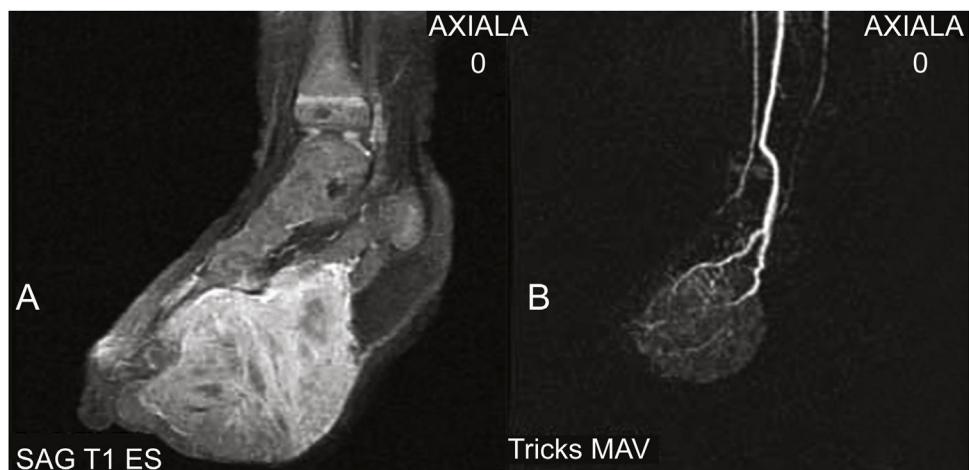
(A) MRI identifying an expansive mass with diffuse contrast enhancement. (B) MRA showing an expansive lesion supported by vascular structures. There is no evidence of arteriovenous fistulas or nidus.
